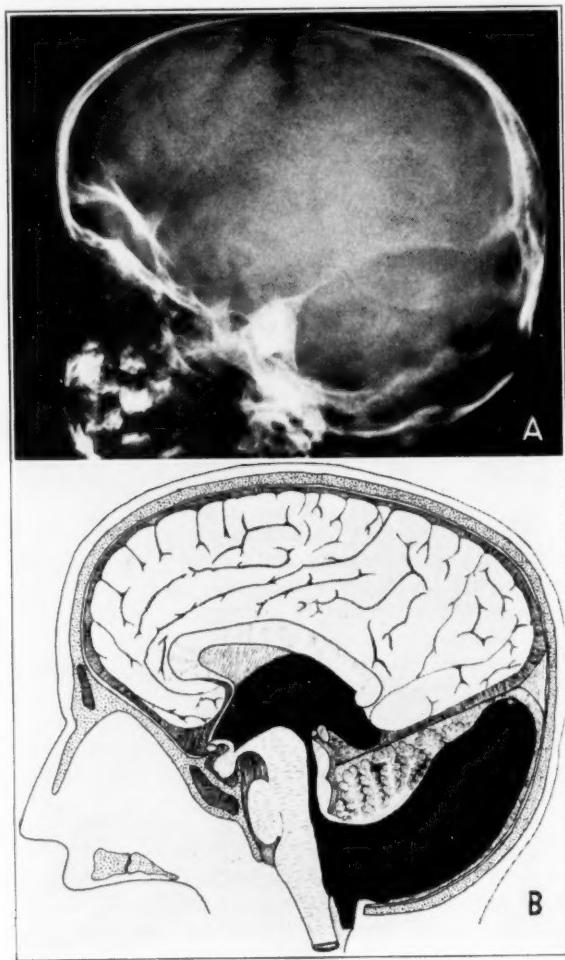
(case 1).—*A*, lateral roentgenogram of the skull, showing the position of the lateral sinus on the inferior margin of the parietal bone and the enormous posterior fossa.
